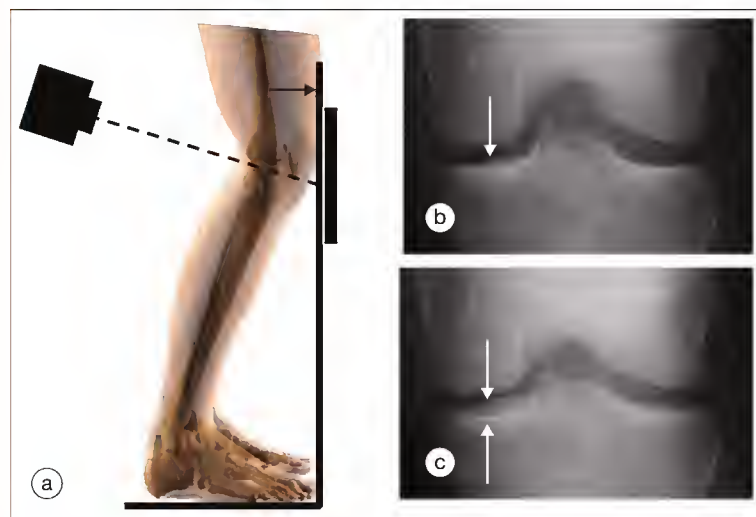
Positioning of the subject for fixed-flexion (FF) and Lyon-Schuss (LS) radiographs and examples of good and poor alignment of the medial tibial plateau (MTP) with the radiographic beam. (a) Positioning of the subject. The FF protocol uses a fixed 10-degree caudal radiographic beam and positions the thighs, patellae, and pelvis flush with the film cassette and coplanar with the tips of the great toes, which results in a fixed knee angulation of approximately 20 degrees of flexion. In the LS protocol, positioning is identical to that for an FF view. However, the angle of the radiographic beam is not fixed but is adjusted for each examination to align the MTP with the radiographic beam. Alignment is achieved with fluoroscopy to superimpose (within 1.5 mm) the anterior and posterior margins of the plateau. (b) Good alignment, as defined by virtual superimposition of the anterior and posterior margins at the center of the plateau (arrow). (c) Radiograph with poor alignment, as depicted by the wide separation (>1.5 mm) of the anterior and posterior margins of the MTP (arrows) or so-called inter-rim distance. (Reproduced with the authors' permission from Merle-Vincent F, Vignon E, Brandt K, et al. Superiority of the Lyon Schuss view over the standing anteroposterior view for detecting joint space narrowing, especially in the lateral tibiofemoral compartment, in early knee osteoarthritis. *Ann Rheum Dis* 2007;66:747-53.)
